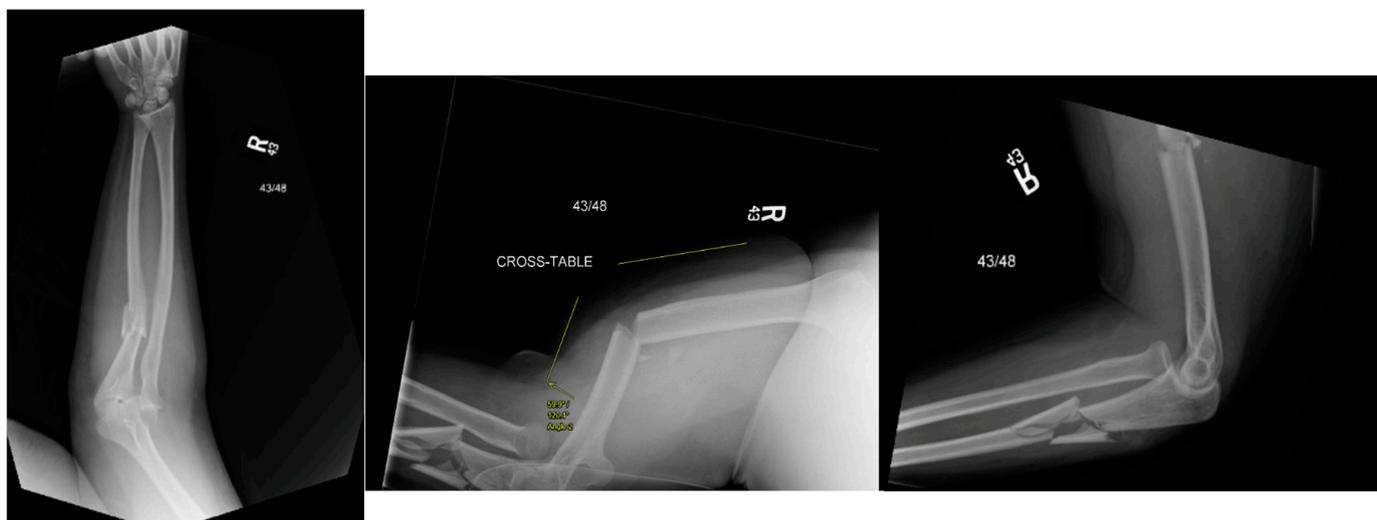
AP, lateral, and cross-table lateral radiographs of right elbow and humerus demonstrating Type I Monteggia fracture with humerus fracture at the time of injury.
